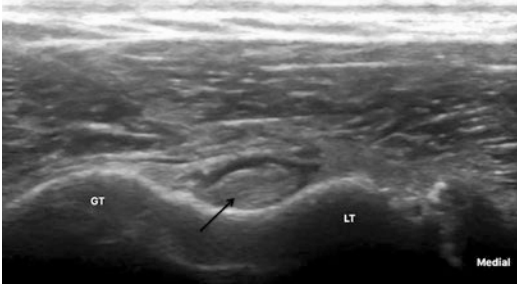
Ultrasound of the proximal biceps brachii long head tendon (*arrow*) in short axis coursing through the bicipital groove. Hypoechoic fluid is seen surrounding the tendon. Greater (GT) and lesser (LT) tuberosities are labeled
